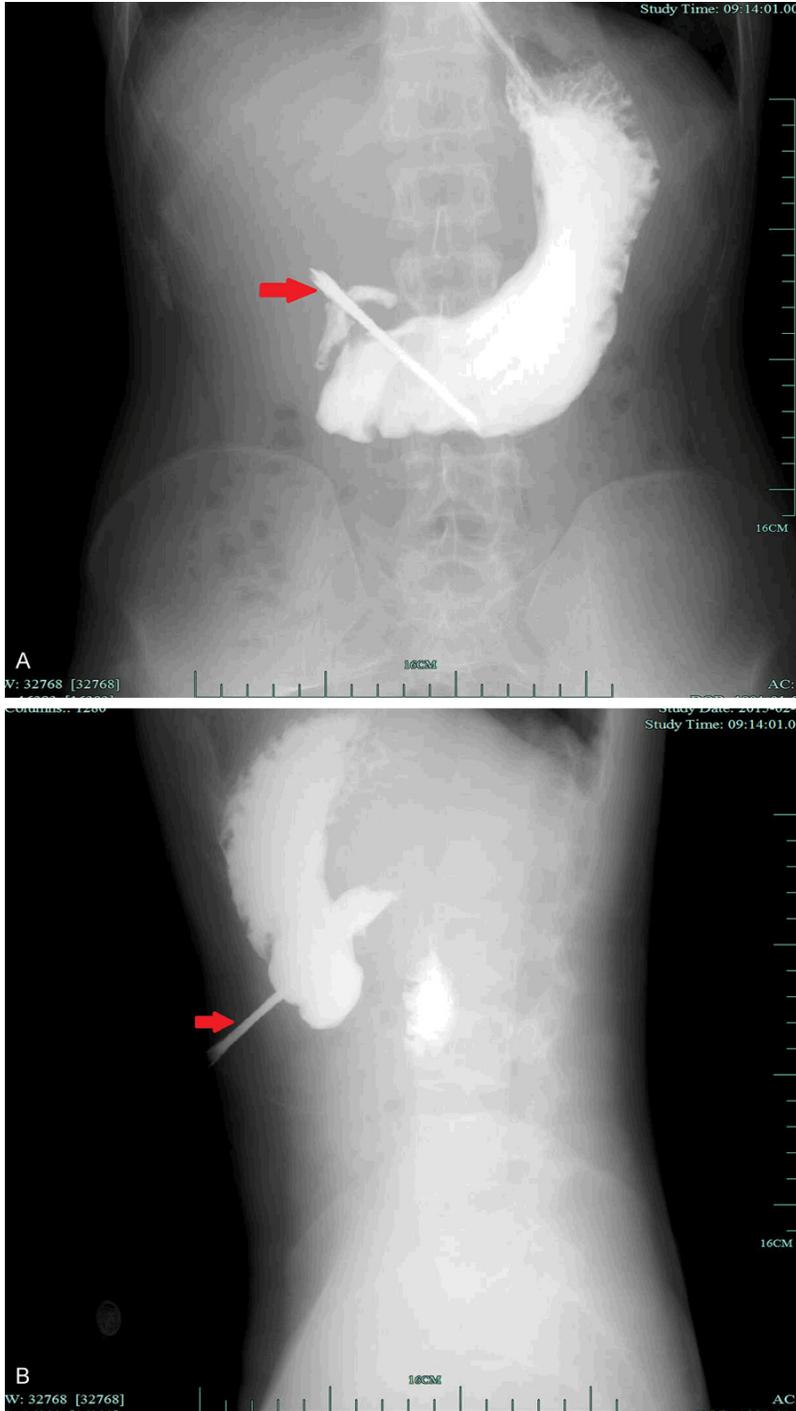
An upper gastrointestinal radiography, which demonstrates in sagittal (A) and coronal planes (B) a long radio-opaque object (red arrow) penetrating the gastric wall, reaching the muscles of the anterior abdominal wall.
